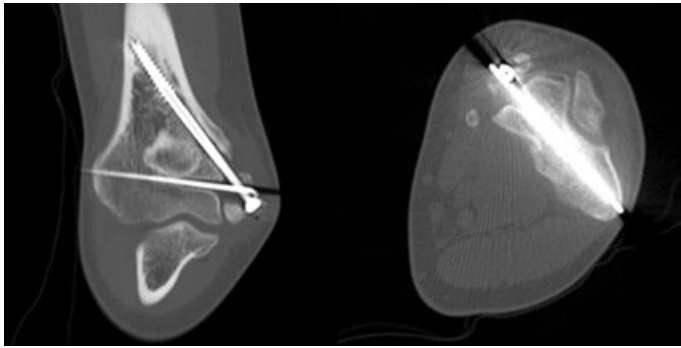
CT at 4 months showing persistent nonunion and fragmentation.
